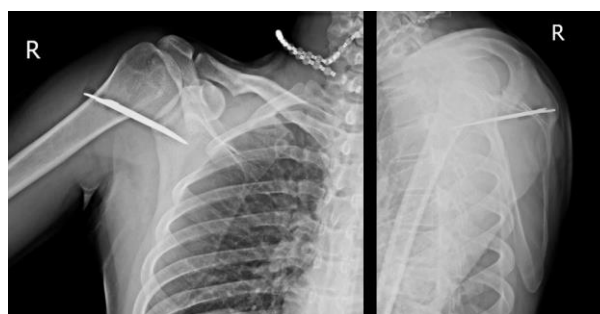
Anteroposterior (AP) and lateral radiographs of the right shoulder
